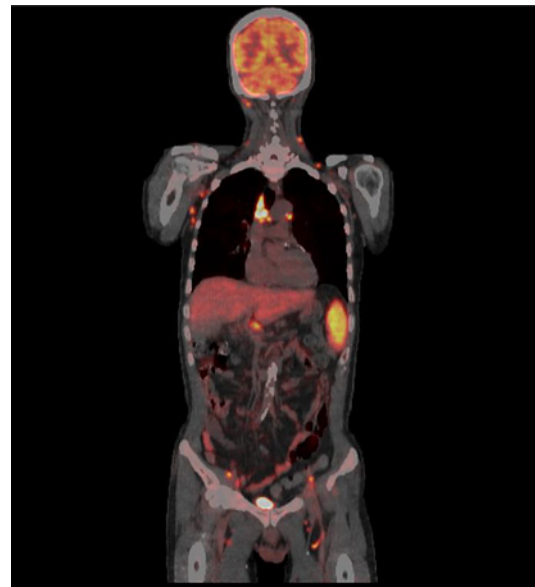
Pretreatment positron emission tomography/computed tomography showing increased accumulation of ^{18}F -fluorodeoxyglucose in multiple lymph nodes and spleen.
